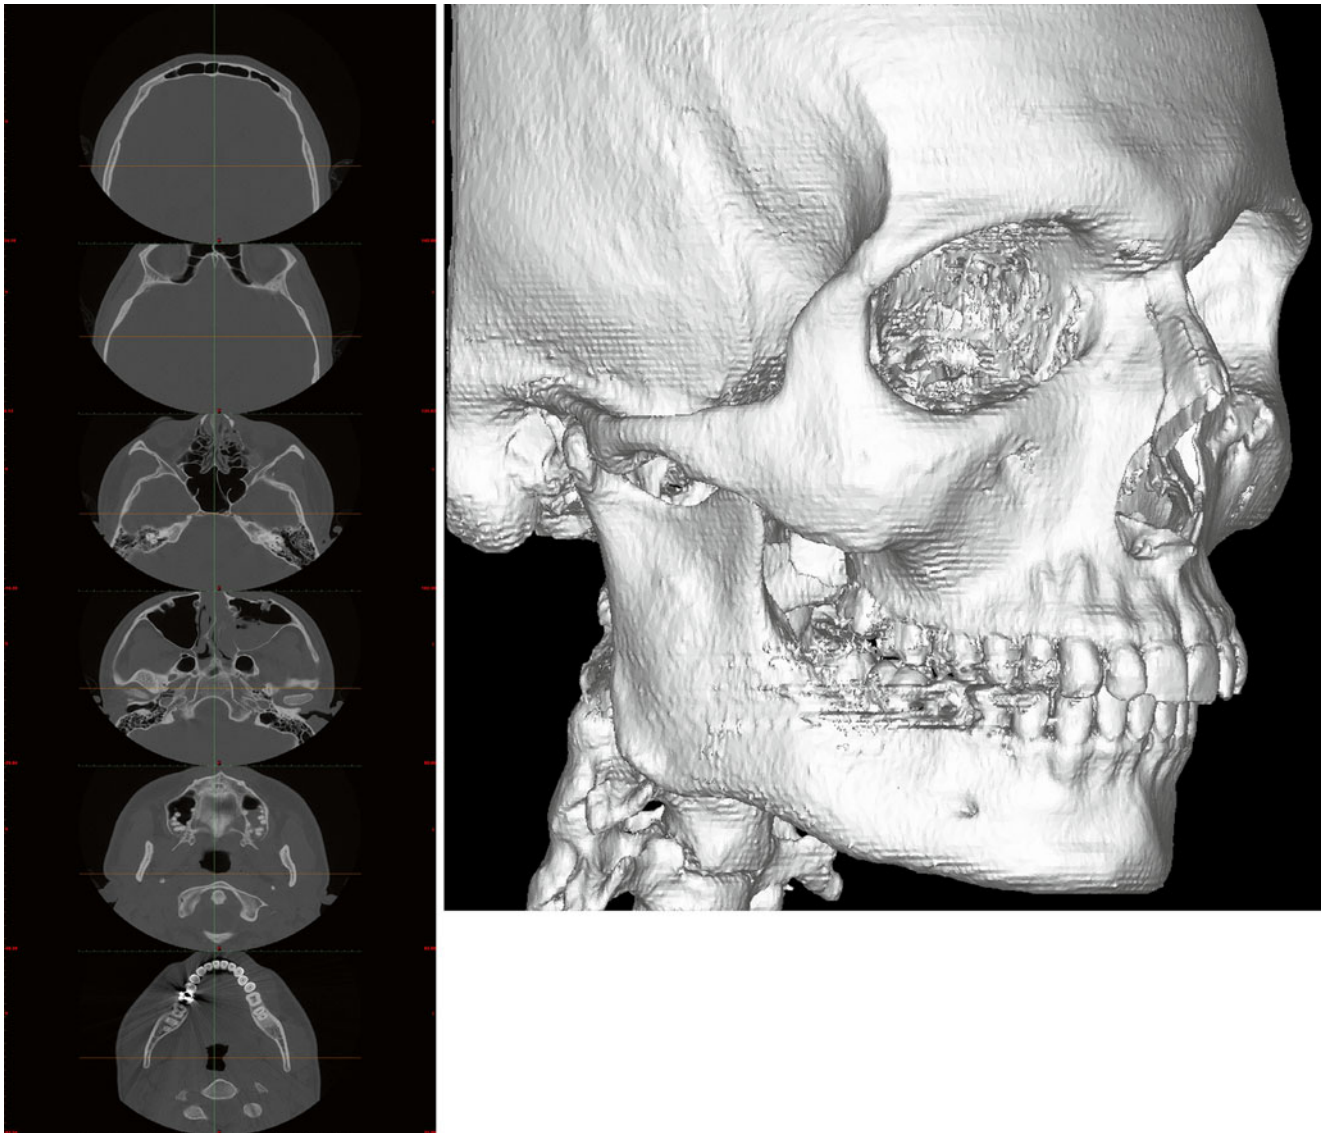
A stack of 2D image slices from CT scan (*left*) is utilized to build a 3D volumetric object (*right*)
